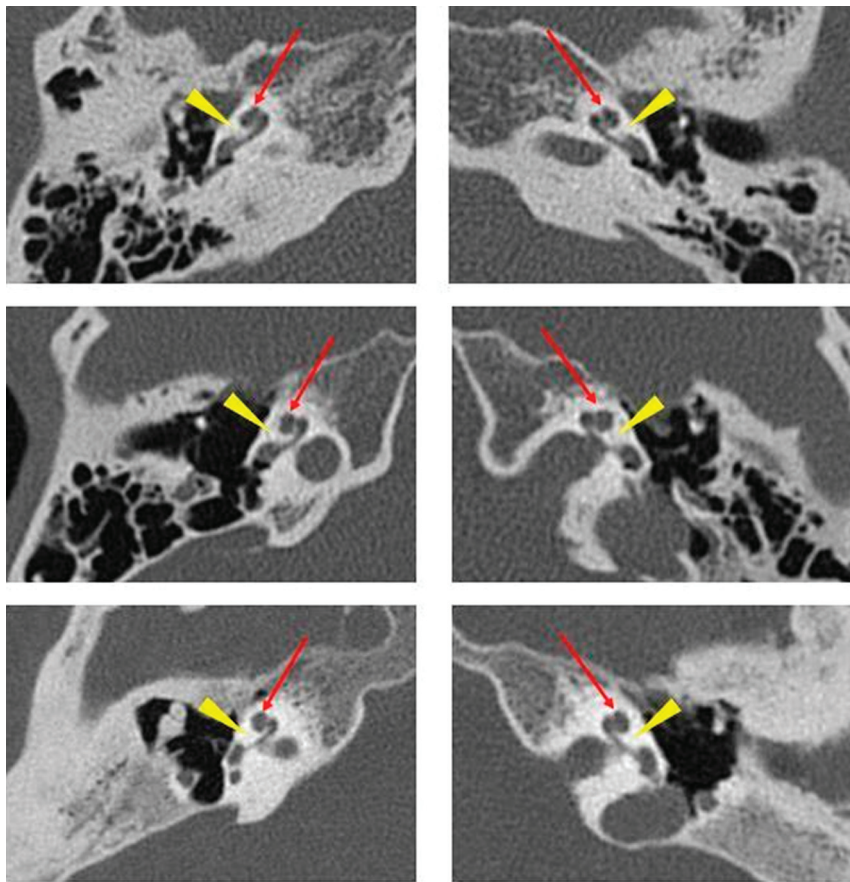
Axial CT images of 3 different patients with *EYA1*-BOR showing the anteriorly offset unwound cochlea, an imaging feature characteristic of *EYA1*-BOR. Notice that the middle and apical turns are anteriorly located relative to the basal turn (red arrows) and slightly tilted away and separated from the basal turn (yellow arrowheads).
